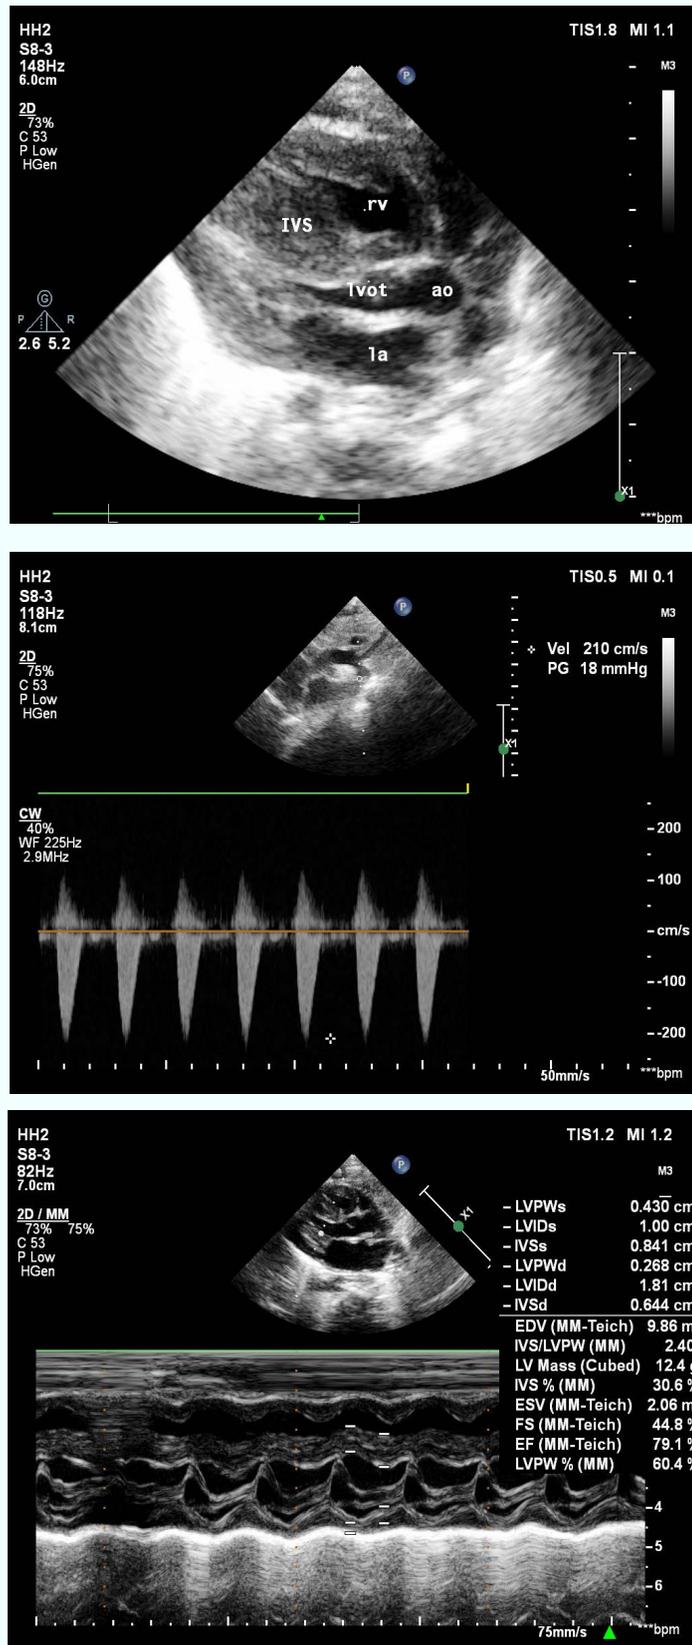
A: M-mode, B: 2-D and C: Doppler echocardiography of the patient showing significant septal hypertrophy and mild coarctation of aorta at first day of life. Septal hypertrophy was diminished dramatically after 4 months without any treatment (D).
